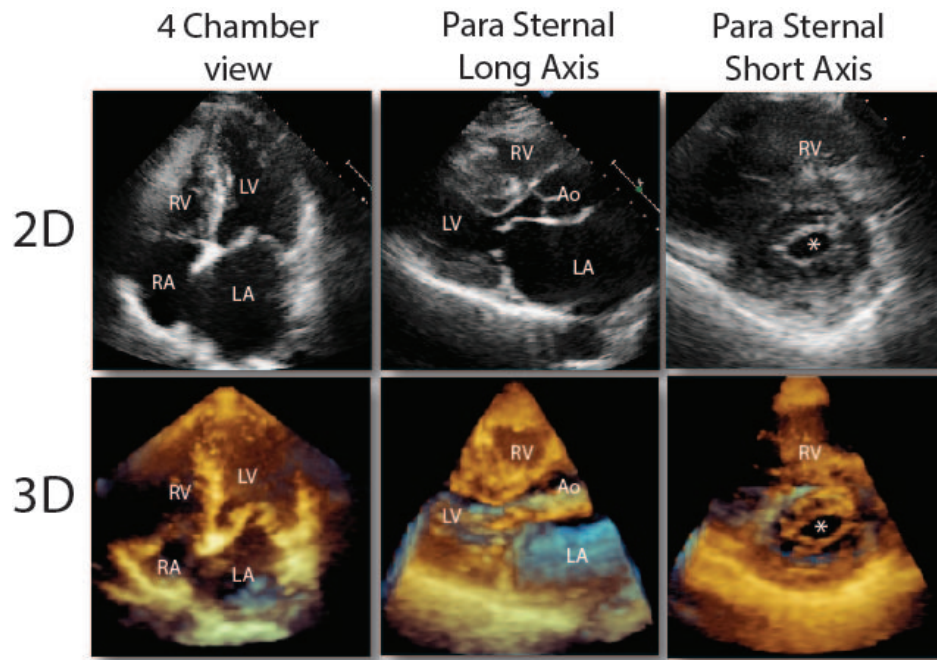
2D and 3D echocardiography of the heart with the 3 most useful views [43].
